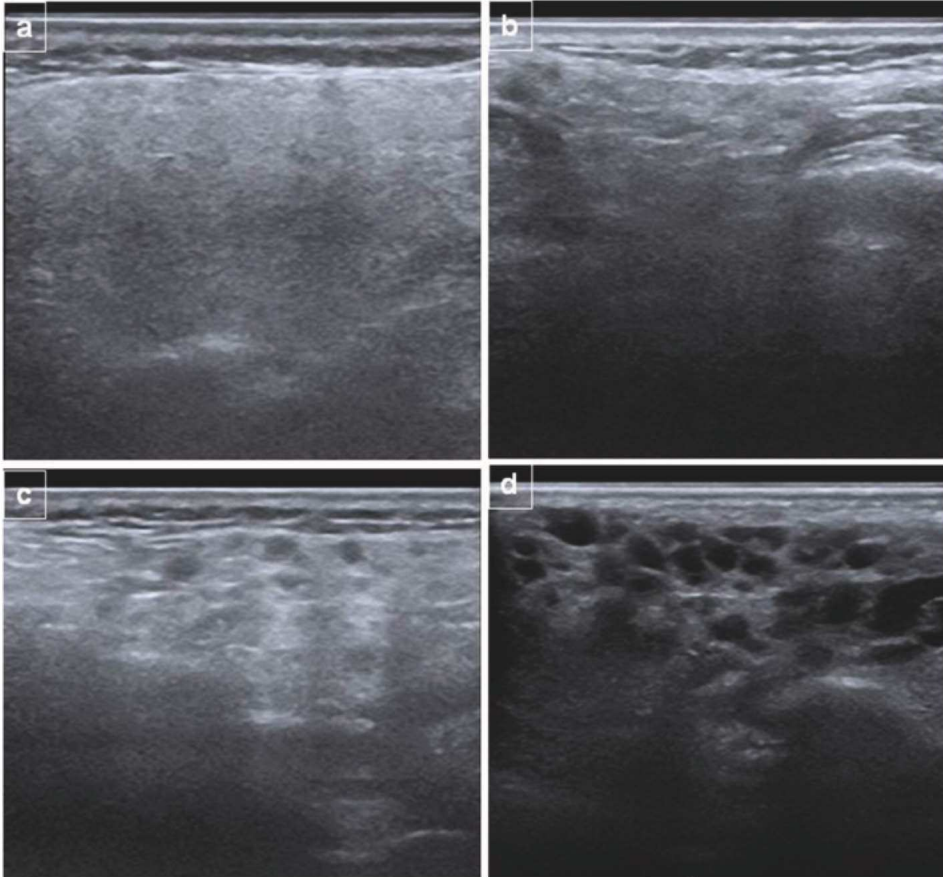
Parenchymal inhomogeneity in the parotid glands demonstrated by ultrasonography. Normal parotid gland, grade 0 (a). Parotid gland with mild non-specific inhomogeneity, grade 1 (b). Parotid gland with evident inhomogeneity, grade 2 (c). Parotid gland with gross inhomogeneity, grade 3 (d). Figure and text from (57).
